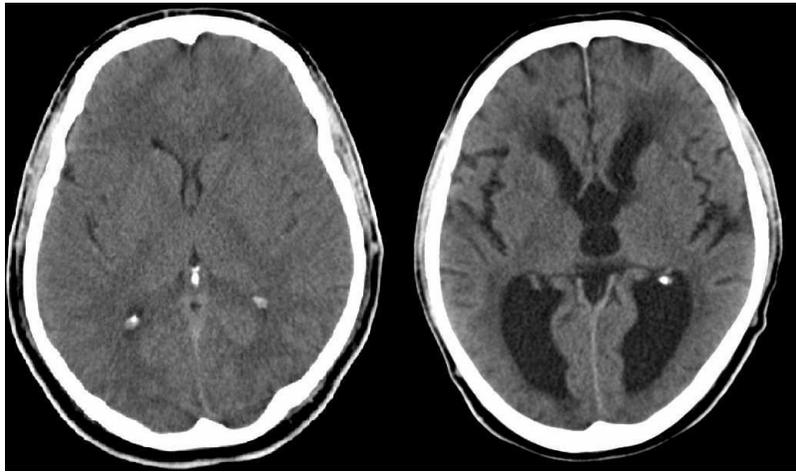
CT scans showing normal ventricles (left), and hydrocephalus (right).
